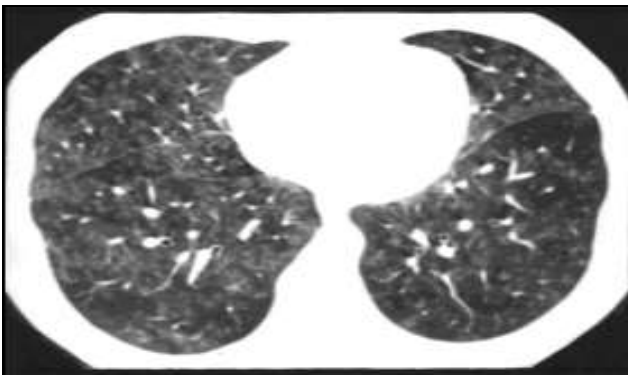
HRCT Thorax of Hypersensitivity Pneumonitis Showing Perihilar Alveolar Infiltrates with Ground Glass Opacities and Mosaic Attenuation
